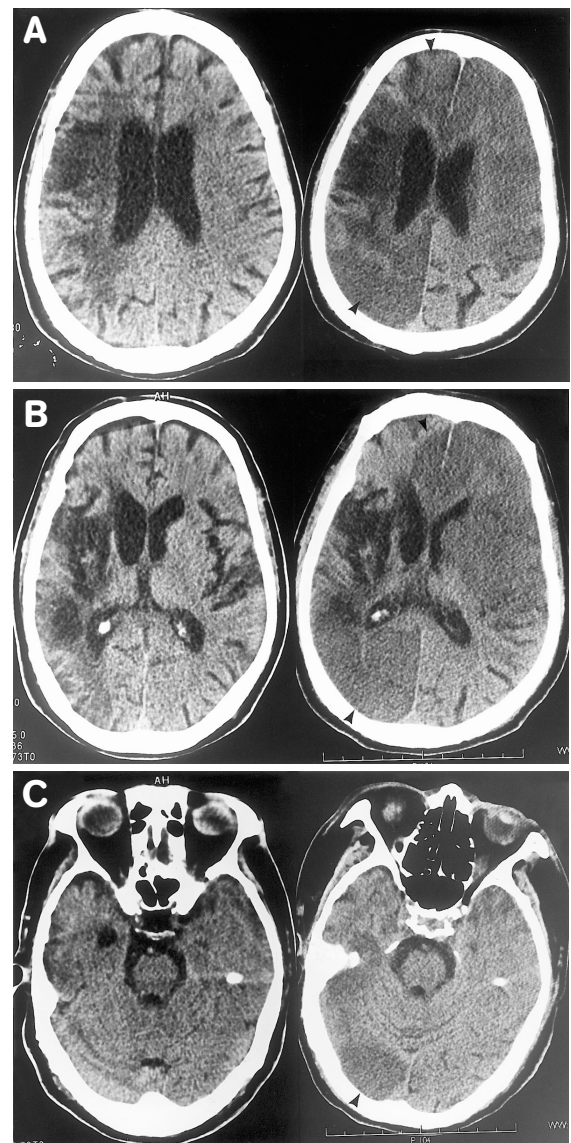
Figure A-C. (Left) Axial sections of brain CT from the emergency room show an old infarction with encephalomalacic changes in the territory of the right middle cerebral artery. (Right) Postoperative follow-up brain CT at the same levels shows new low attenuation lesions in the territories of bilateral anterior cerebral arteries, left middle cerebral artery, right posterior cerebral artery, and right middle cerebral artery (arrowheads).
